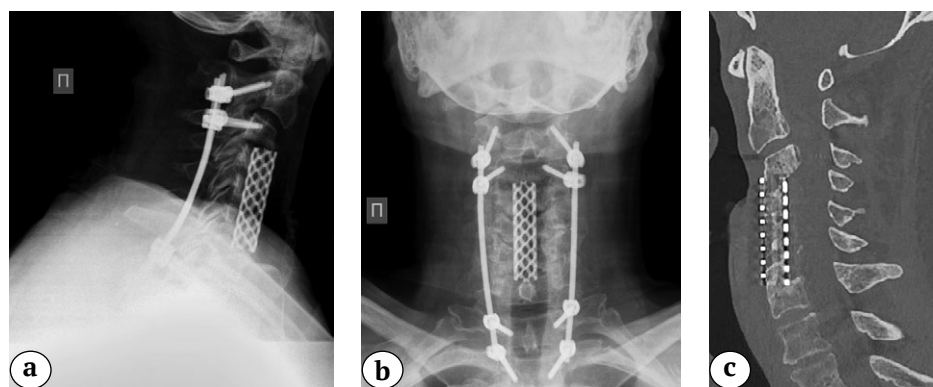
(a, b, c). Sagittal (a) and frontal (b) X-rays, sagittal CT (c) 10 months after surgery: posterior transpedicular screw fixation correct position, solid anterior fusion C3–C7 formation detected
